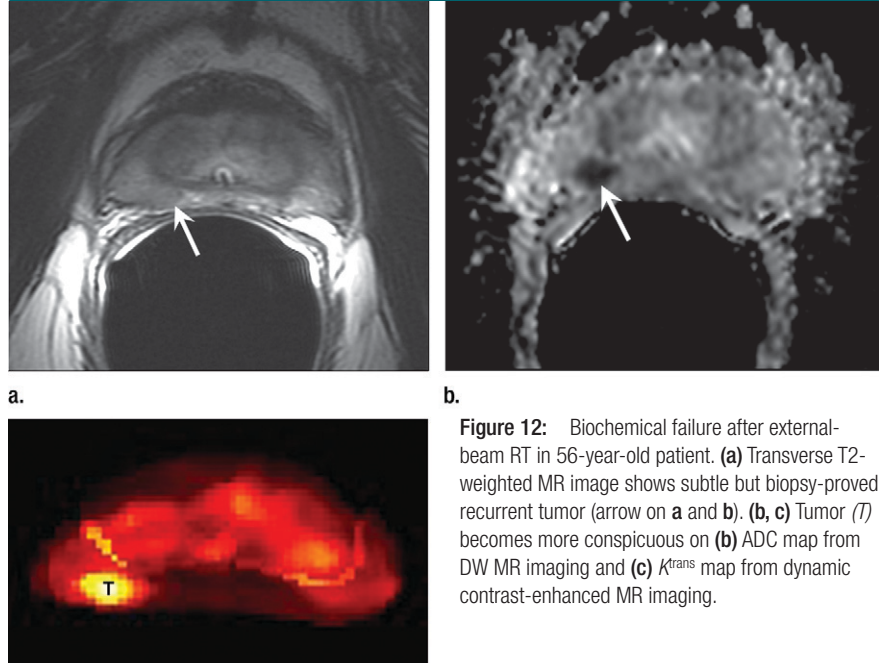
Biochemical failure after external-beam RT in 56-year-old patient. (a) Transverse T2-weighted MR image shows subtle but biopsy-proved recurrent tumor (arrow on a and b). (b, c) Tumor (T) becomes more conspicuous on (b) ADC map from DW MR imaging and (c) K^{trans} map from dynamic contrast-enhanced MR imaging.
